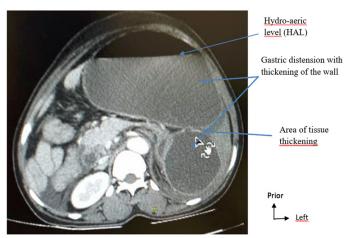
Abdominal CT scan in axial section of gastric volvulus in our patient showing NHA, gastric distension and the gastric plication area (Image from the surgery department of the Ziguinchor Peace Hospital).
